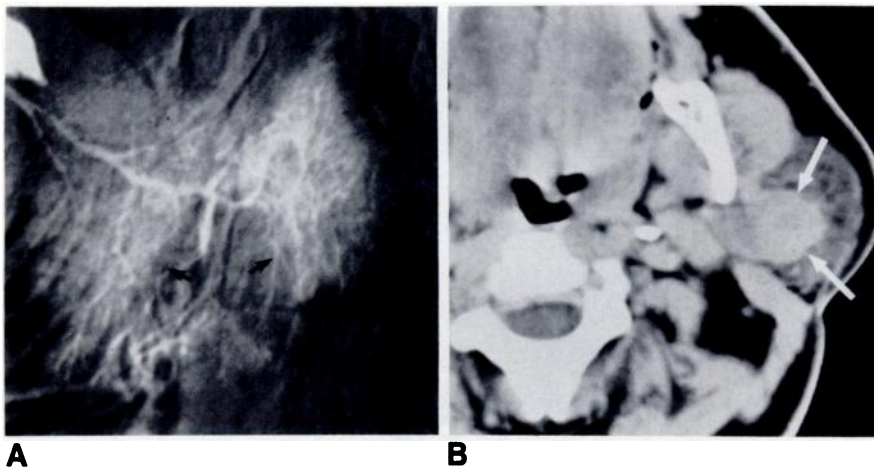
Case 7. A, Digital subtraction sialogram, lateral projection. B, CT scan. Intrinsic mass (white arrows) with displacement and stretching of left parotid parenchyma and ducts (black arrows). Pleomorphic adenoma removed at surgery.
